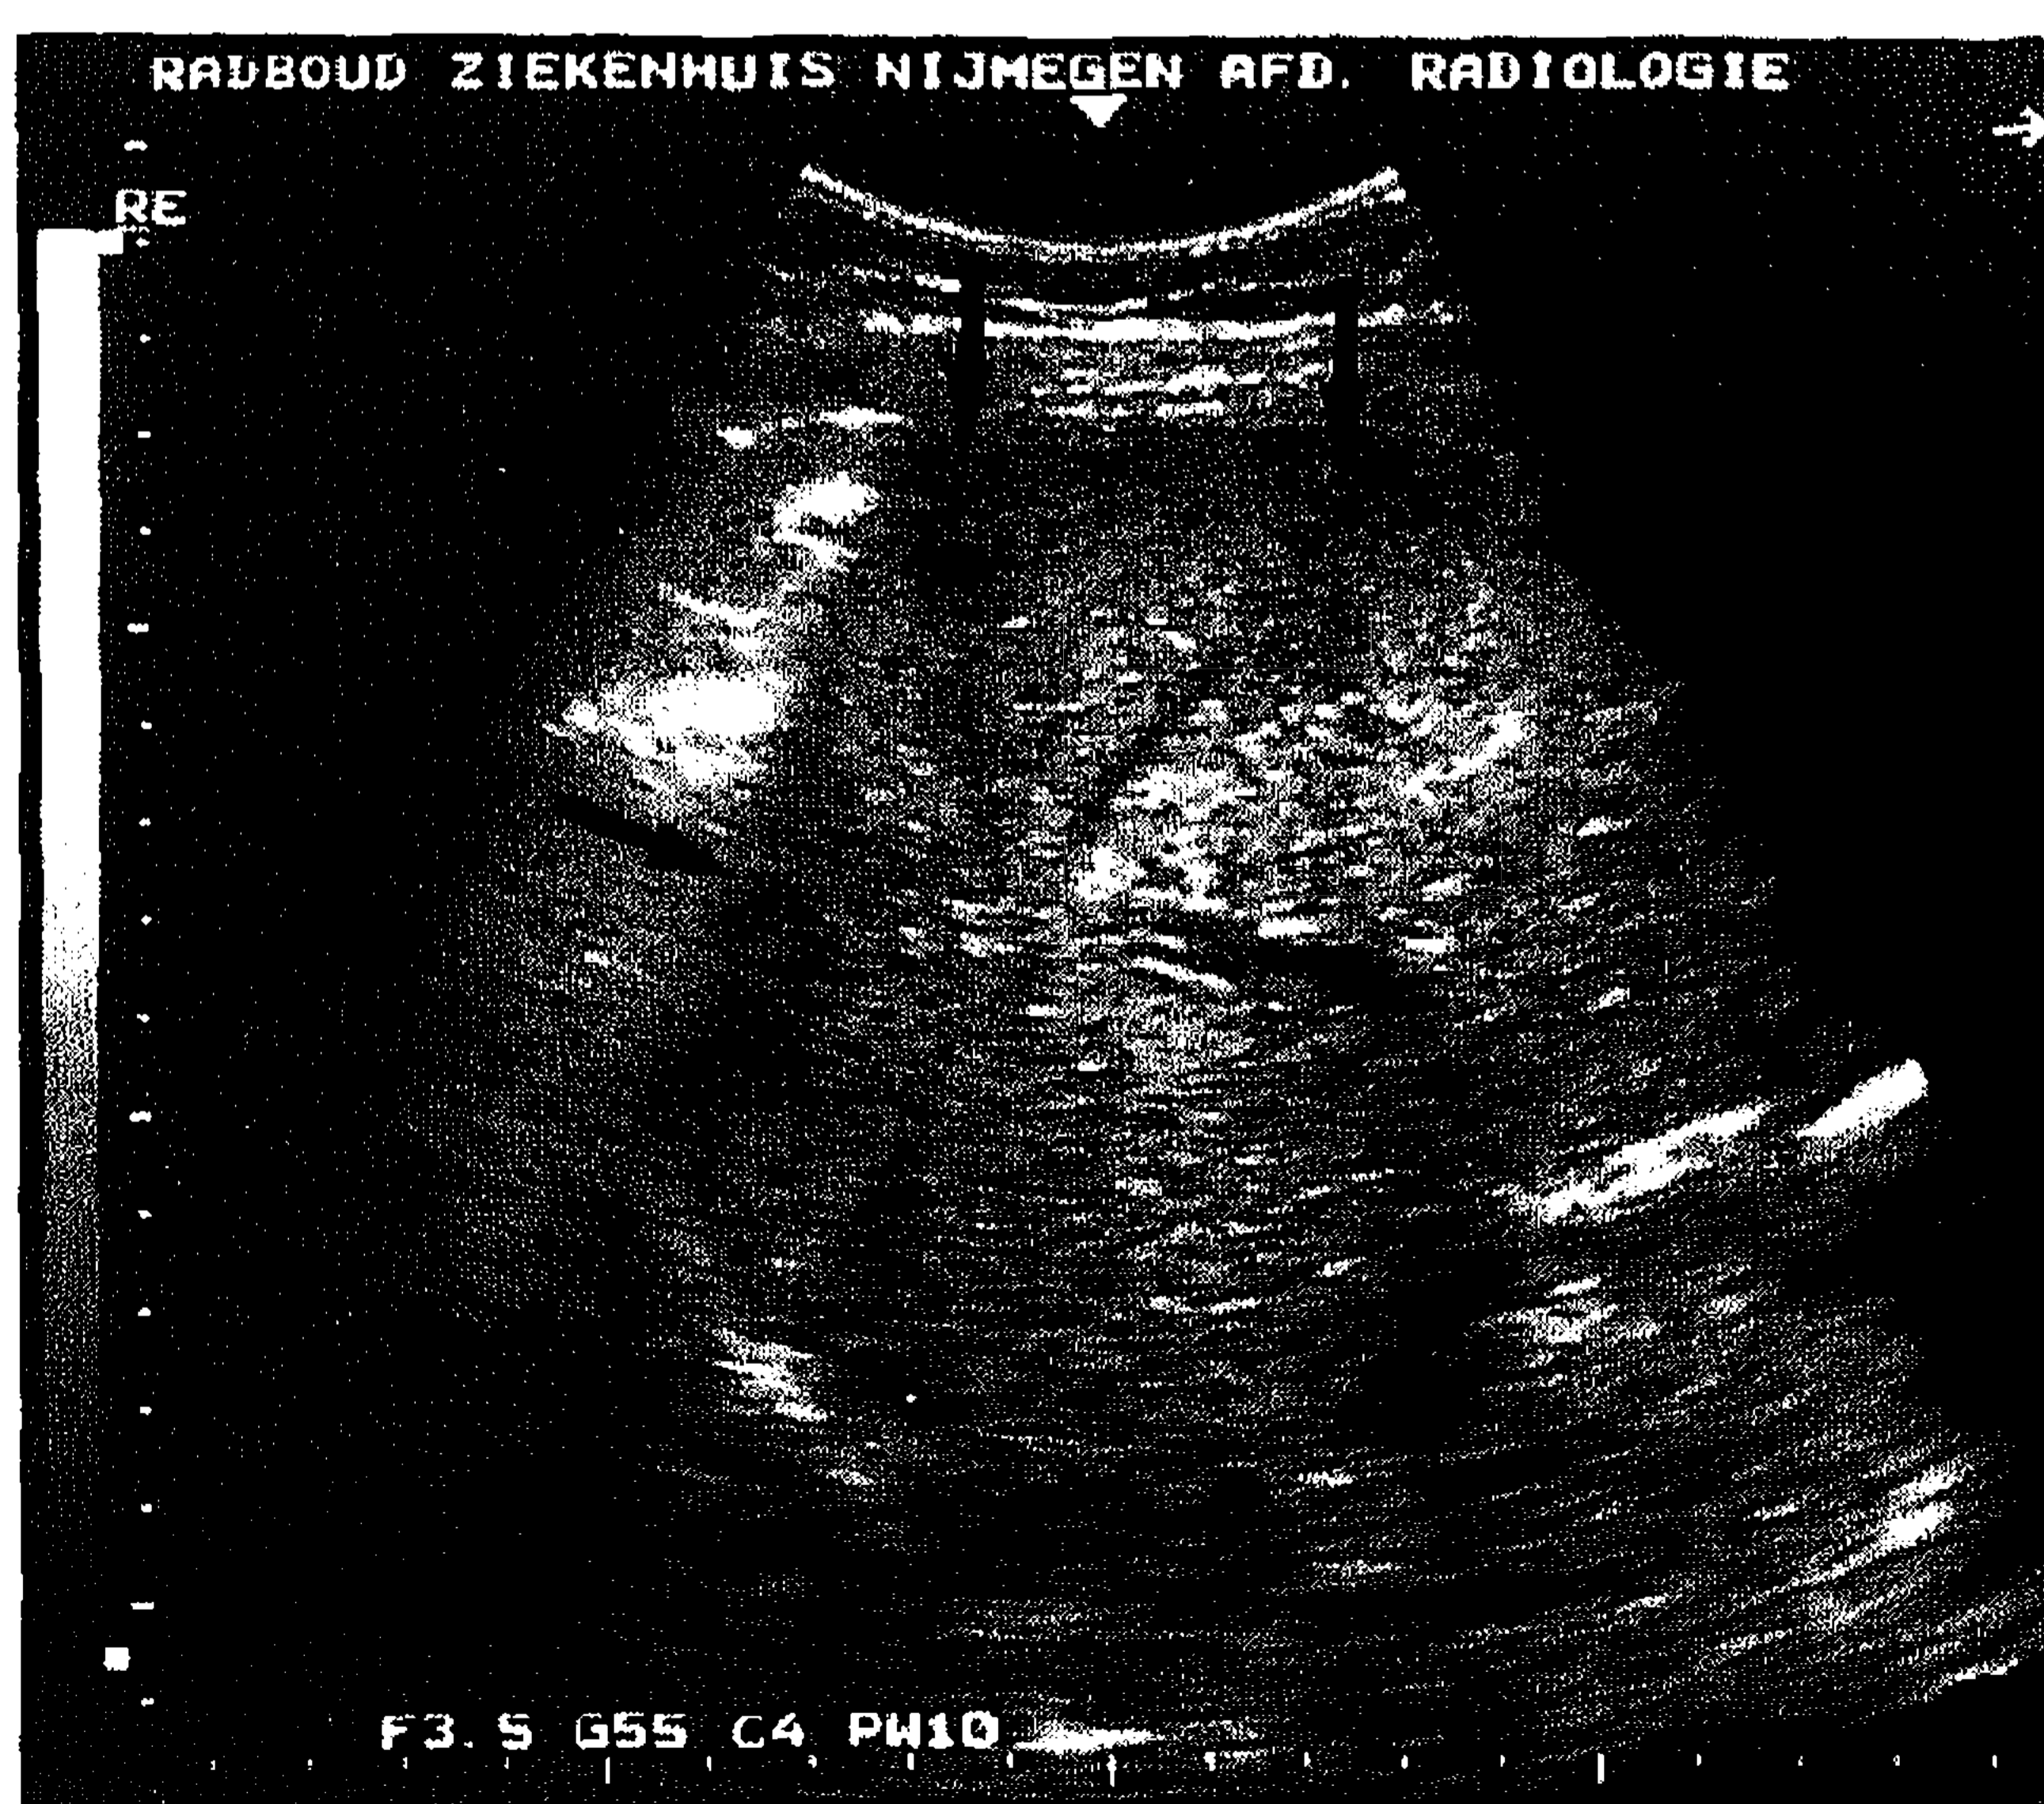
Ultrasound image of the right upper quadrant, demonstrating multiple small subcapsular lesions in the right liverlobe (arrows).
